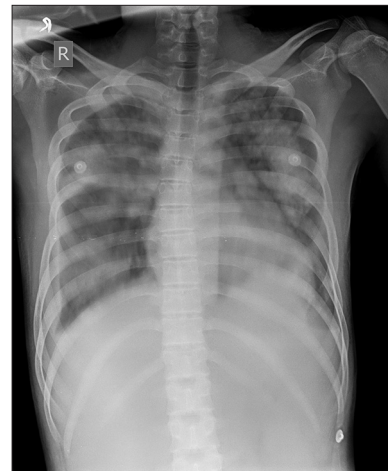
Chest radiography showed bilateral diffuse fluffy infiltrates (case 1)
